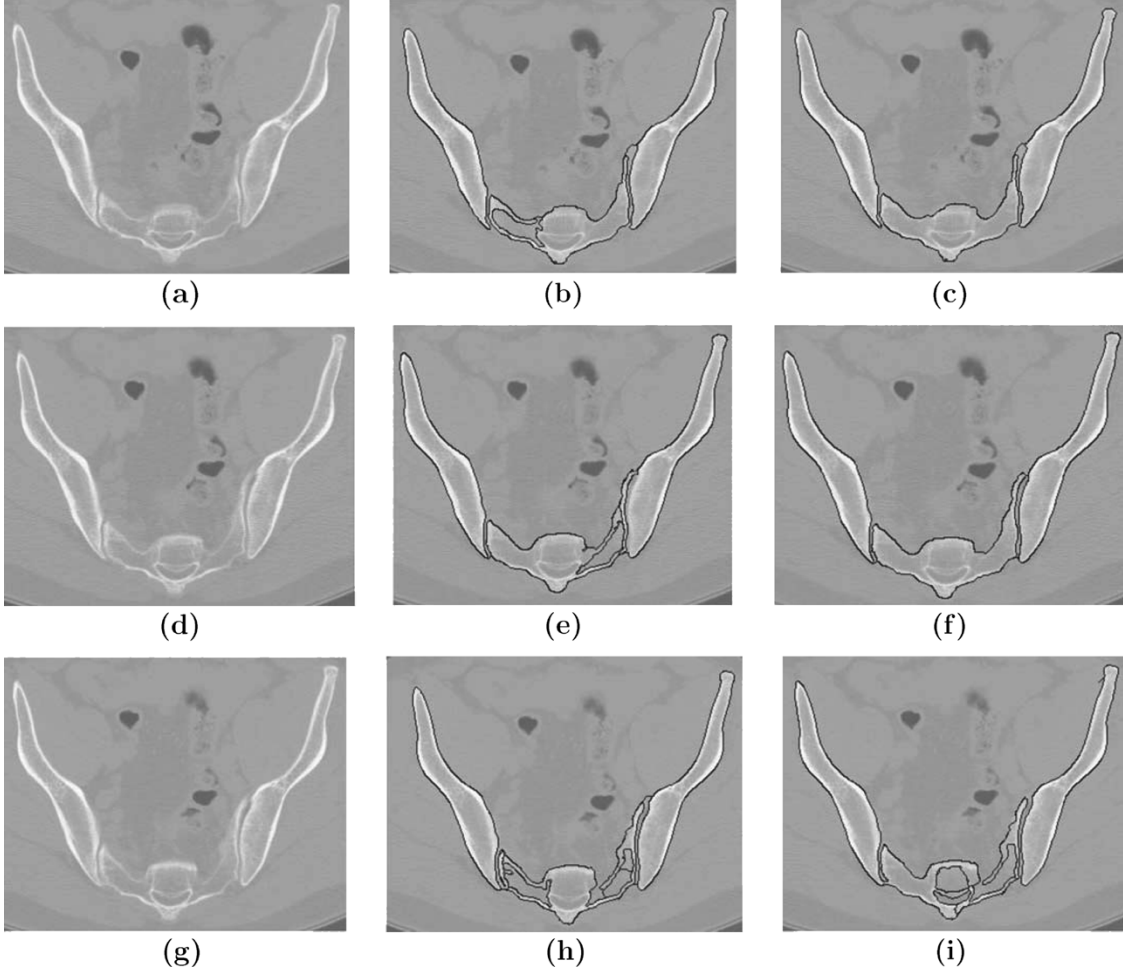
Comparison of segmentation with and without normal-direction correction. (a), (d), (g) Three contiguous original CT slices of a human pelvis. (b), (e), (h) The edge maps, respectively, of the images without correcting the normal direction. (c), (f), (i) The edge maps with the normal direction corrected.
